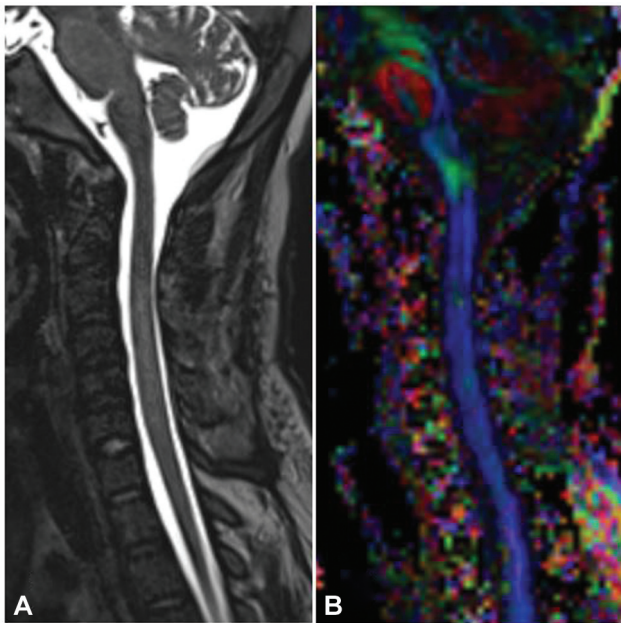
Postoperative magnetic resonance imaging: (A) Sagittal T2-weighted sequence with normal cord without evidence of cerebrospinal fluid leak and (B) diffusion tensor imaging tractography with intact tract continuity and thickness.
